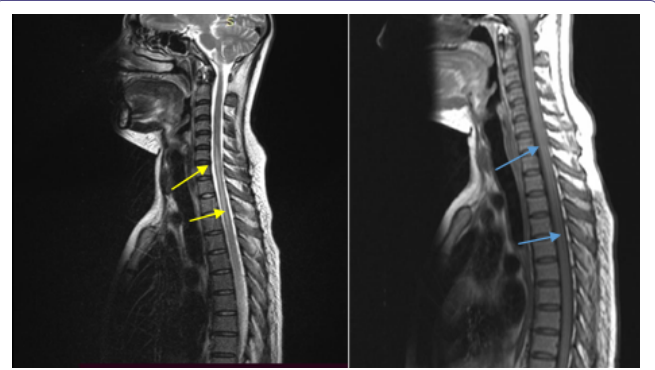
MRI CERVICODORSAL Spine T2(A) sagittal view showed hyperintense signal from C6 to T9 pointed out by yellow arrows (B) T1sagittal view showed abnormal signal from C6 to T9 indicated by blue arrows.
